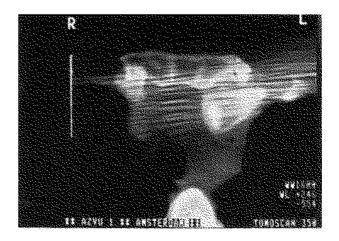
Computed tomography in patient B.
